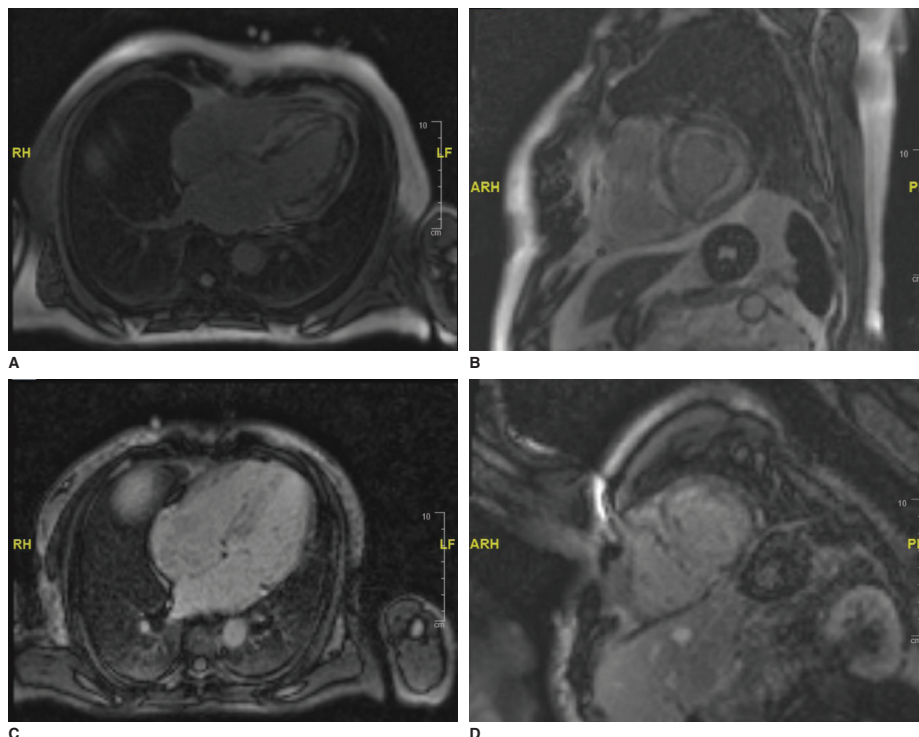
Two examples on cardiac MRI of early cardiac amyloidosis with subendocardial delayed enhancement (A and B) and late-stage disease showing full thickness delayed enhancement (C and D).
